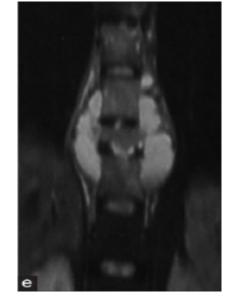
MRI of spinal tuberculosis: (a, c-sagittal; b, d-axial; ecoronal) images showing vertebral lesion hypo on T1 and hyper on T2W images, epiphyseal and discal involvement with anterior and paraspinal extension.
